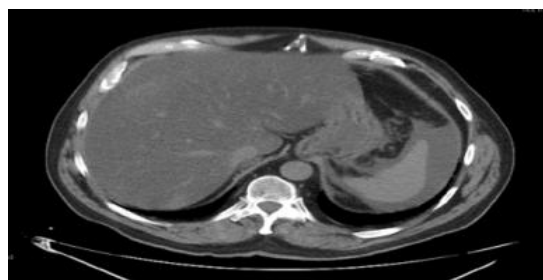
CT images - cross section with free gas: Abdomen: transhepatic/transsplenic cross section.
